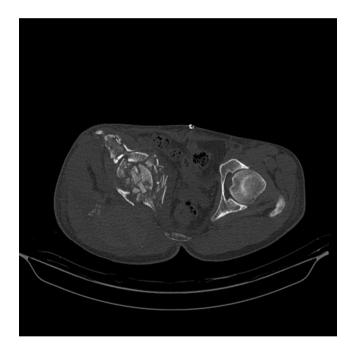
Axial CT scan demonstrates severe comminution of the right acetabulum and femoral head.
